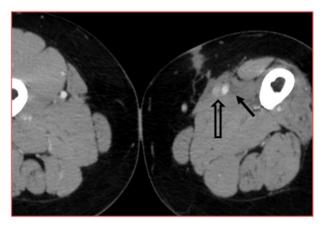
Postoperative CT image showing that the reconstructed artery (black arrow) and vein (white arrow) are patent.
